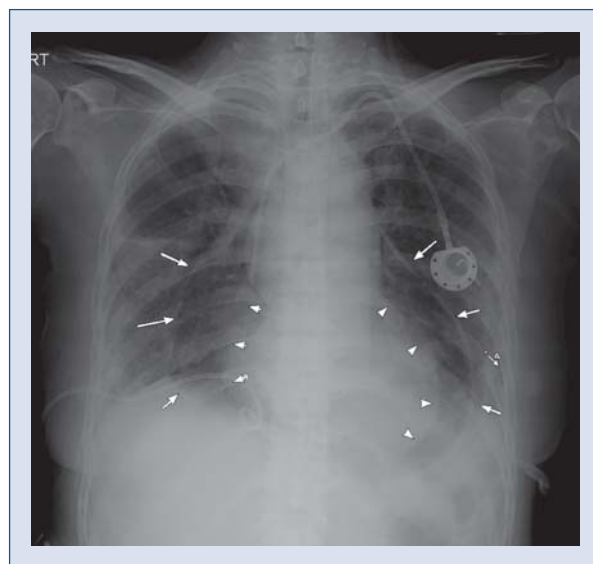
The chest X-ray showed two obvious radiolucent areas (arrow and arrow head) along both heart borders, suggesting accumulation of air in pericardium space (pneumopericardium). The catheter in this picture was placed in the pleural space to remove malignant pleural effusion.
